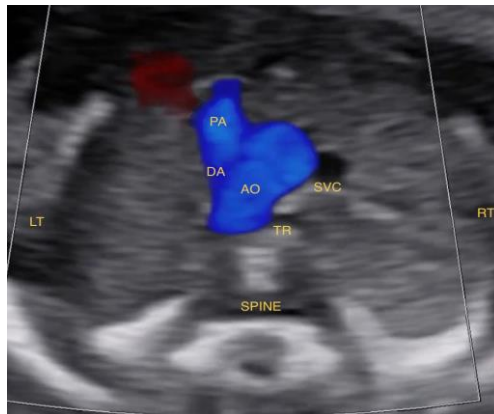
Three-vessel and trachea (3VT) view with color Doppler demonstrating normal alignment of the great vessels.
